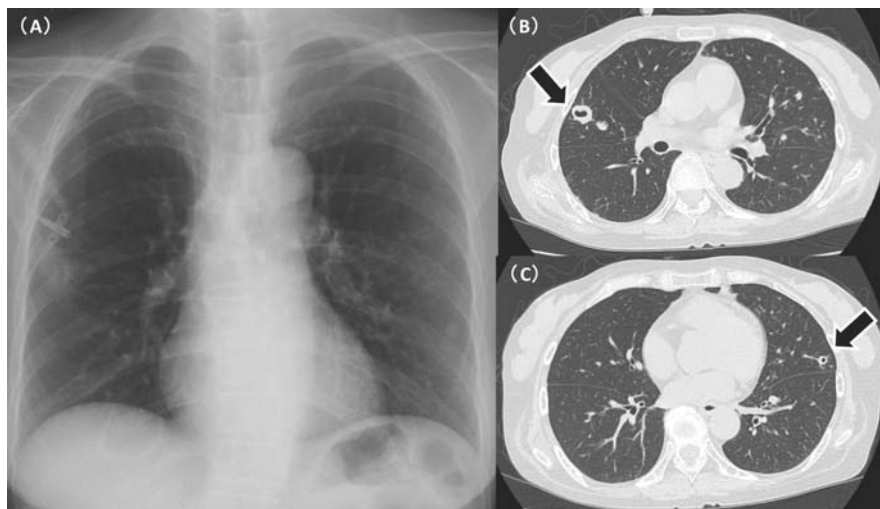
Radiograph and computed tomography of the chest performed on Day 1 of hospital admission
